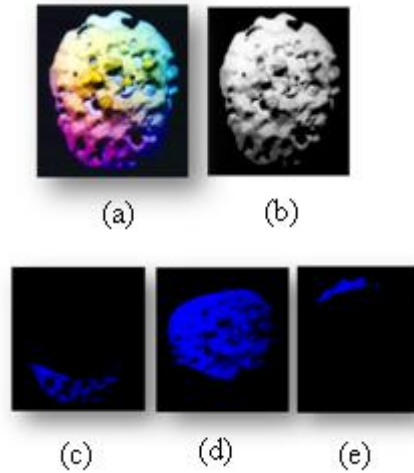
(a) SPECT image (View Type: Surface). (b) Gray Scale Image. (c) Occipital lobe. (d) Parietal lobe (e) Frontal lobe
